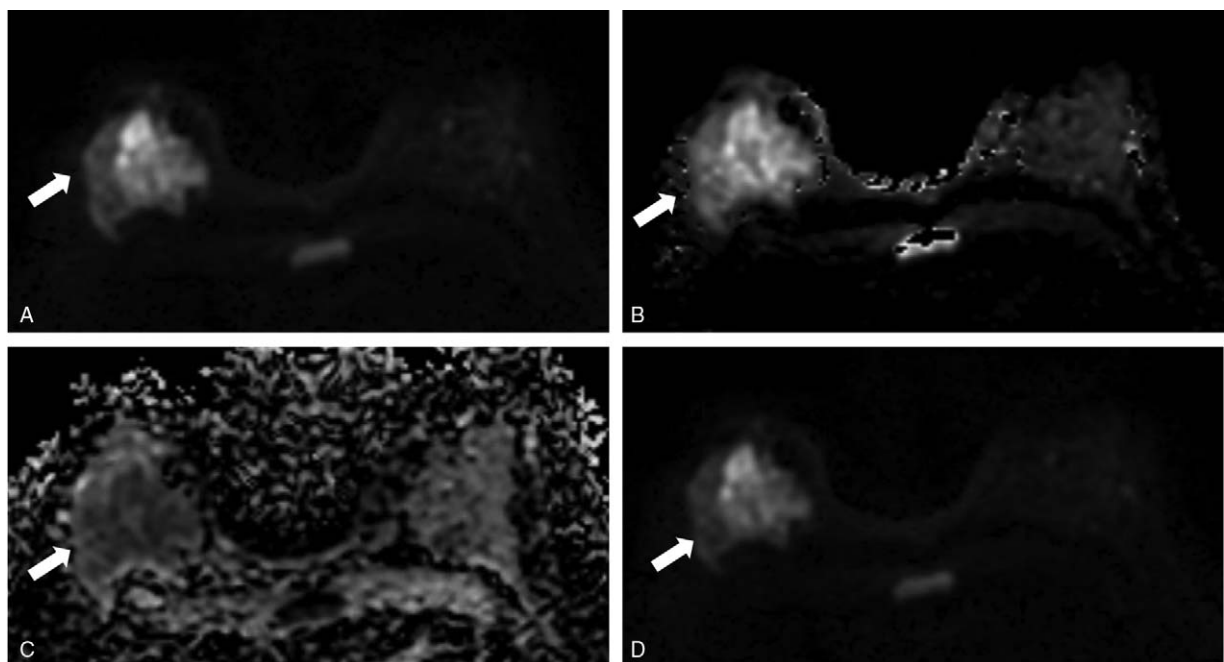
Images of a 37-year-old woman with an invasive ductal breast carcinoma in the right breast (arrow). (A) DWI with $b=800\text{ s/mm}^2$; (B) b-value map; (C) ADC map; and (D) cDWI with b value of 1000 s/mm^2 . The b-value map manifested best signal difference within the lesion than $\text{DWI}_{b=800}$ and optimal cDWI_{1000} . ADC=apparent diffusion coefficient, cDWI=computed DWI, DWI=diffusion-weighted imaging.
